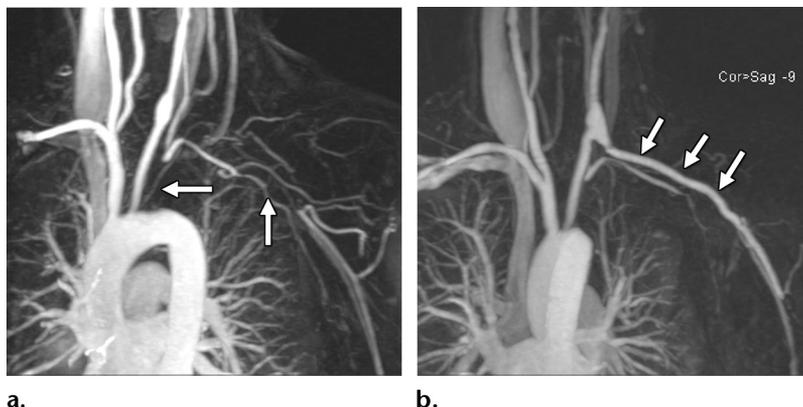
Graft occlusion in a patient with recurrent symptoms after left thoracic outlet decompression with left carotid-to-subclavian artery bypass. (a) Coronal arterial phase MIP from subtracted phase GRE imaging with the arms down shows occlusions of the proximal and mid left subclavian artery (arrows). The left carotid-to-subclavian artery graft was occluded, but does not appear on this image and could easily be missed if the patient's operative history was not known. (b) MR image after thrombolysis of the graft shows restored flow (arrows).
